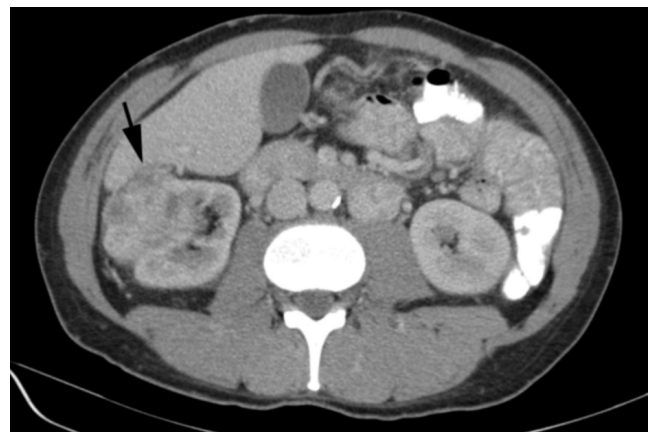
50-year-old man with renal-cell carcinoma. Post-contrast axial CT image of enhancing primary renal-cell carcinoma of the right kidney (arrow).
